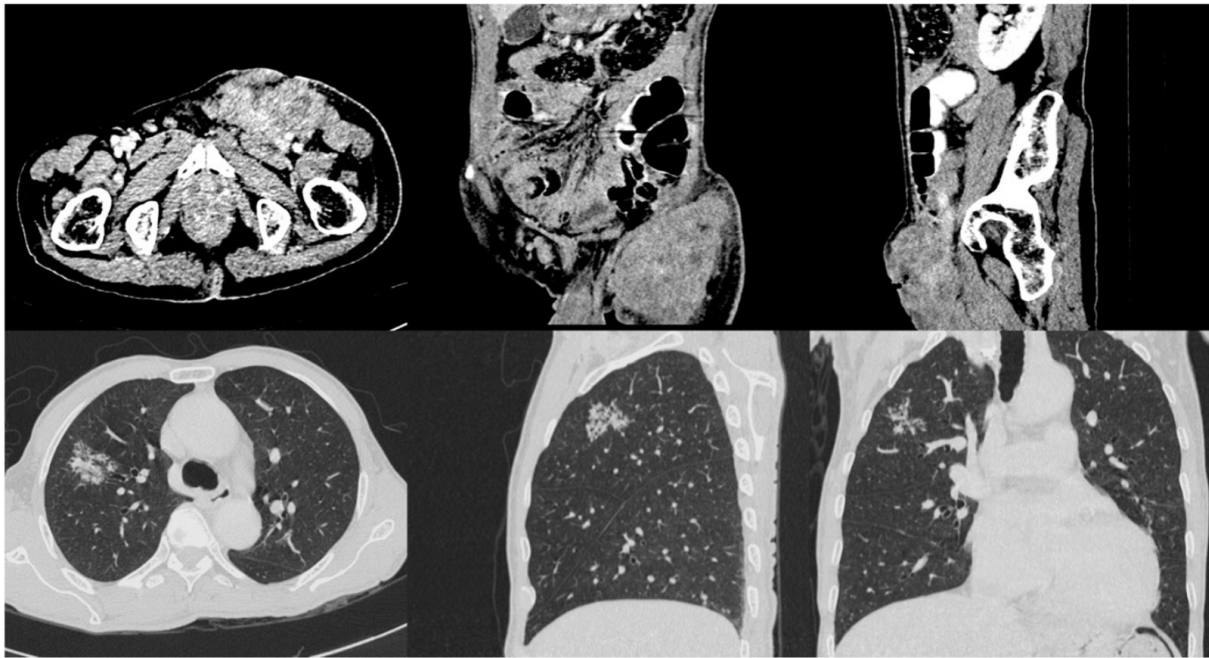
Initial CT scan of the thorax, abdomen and pelvis showed a left inguinal heterogeneously enhancing mass measuring 5.8 cm x 11.2 cm x 9.4 cm (AP x W x CC), with a central non-enhancing region likely due to necrosis. Anteriorly, there is superficial ulcerating extension of this mass, with poor fat plane with the adjacent vessel and muscles. Part of the left superficial femoral vein was compressed with partial encasement by this mass; however, no obvious filling defect seen. There were focal tree-in-buds densities in the right upper lobe however, no enlarged intrathoracic lymph nodes
